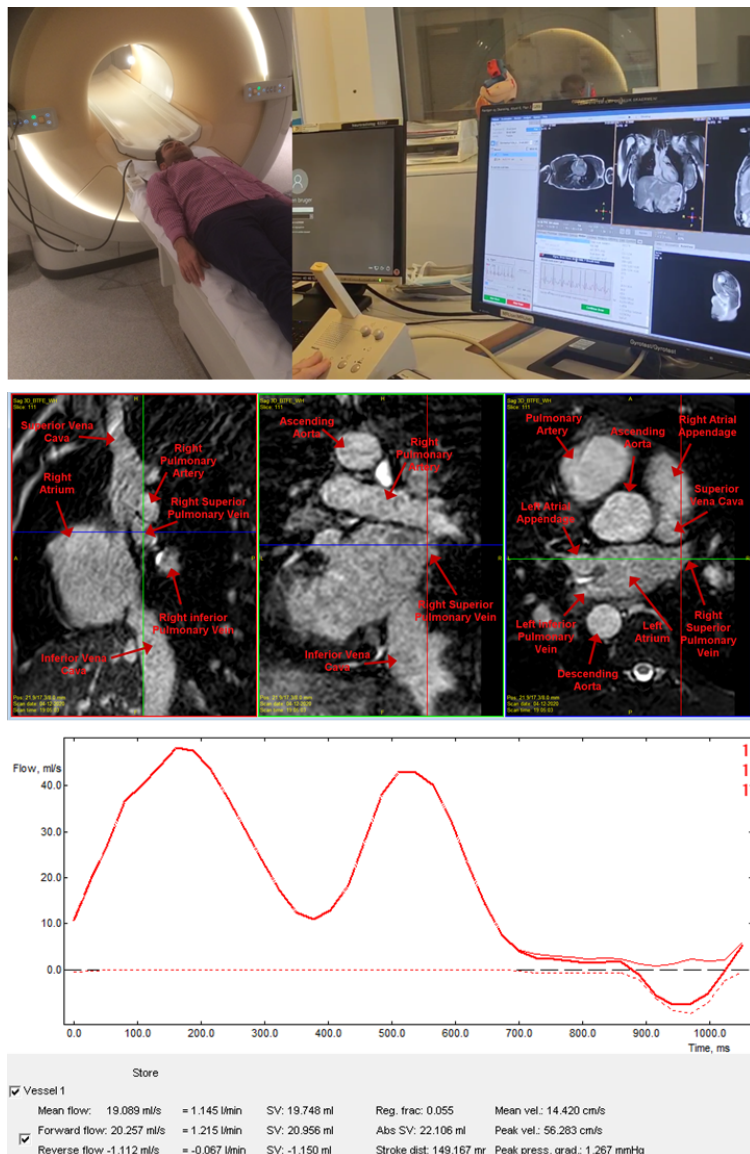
The in-vivo PC-MRI procedure is shown in the figure. The upper panel displays the author as one of the volunteers in the magnetic resonance scanner, and the control room. The middle panel shows an example of post-processing of the sagittal, axial, and coronal views of the images in the Siswin software. All the cardiac structures are landmarked on the image. The lower panel displays a measured LSPV flowrate profile.
